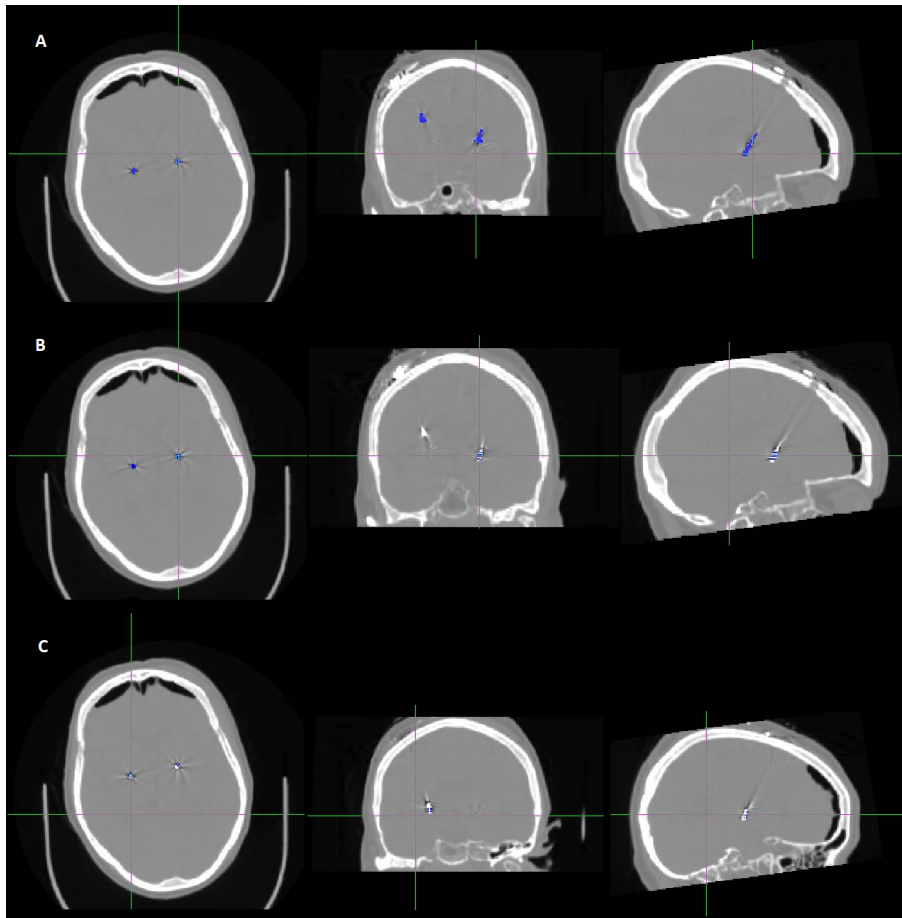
Fusion of CT images with: (A) The DBS lead mask obtained after the 3D labelling connect components algorithm; (B) electrodes mask obtained by the automatic algorithm; (C) electrodes mask obtained by the semiautomatic algorithm.
